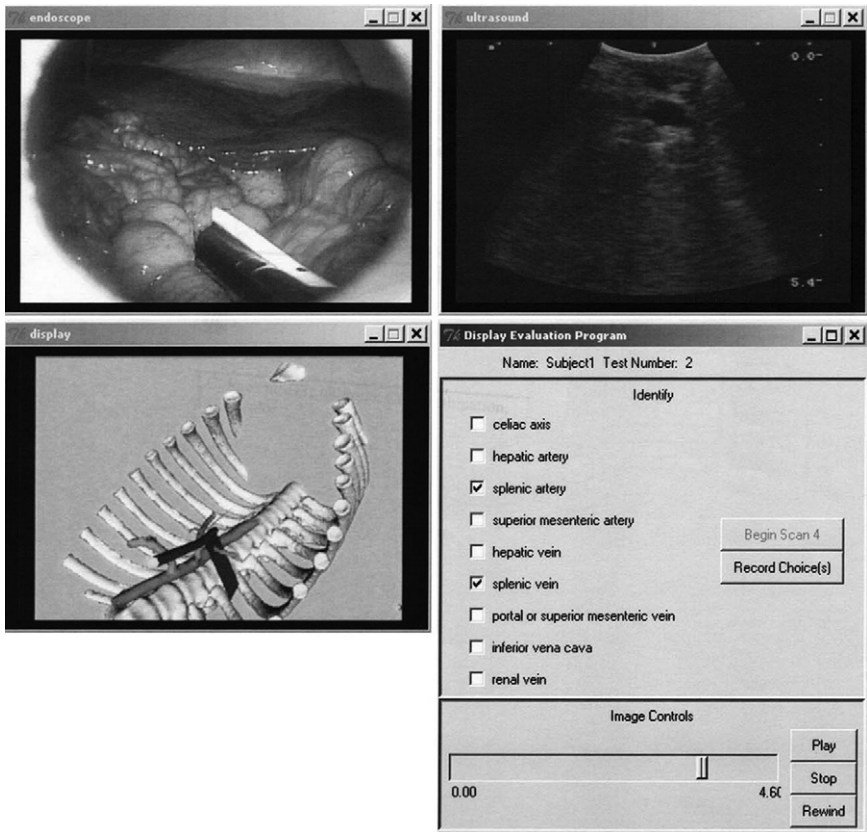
Screen shot of testing software showing laparoscopic view including view of ultrasound probe (upper left), ultrasound image from intra-abdominal probe (upper right), segmented CT image showing probe position and field of view (lower left), and selection panel for segmented CT image. (Reprinted with permission from Ellsmere et al.⁴²)
